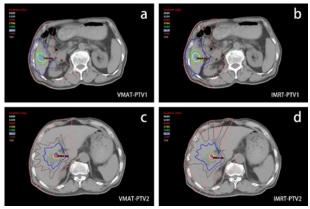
Dose distributions of axial computed tomography scans for VMAT and IMRT plans for one case. (a) Isodose lines of the VMAT plan for PTV1, (b) isodose lines of the IMRT plan for PTV1, (c) isodose lines of the VMAT plan for PTV2, (d) isodose lines of the IMRT plan for PTV2. Isodose lines show 110% (66 Gy, white), 105% (63 Gy, cyan), 100% (60 Gy, red), 95% (57 Gy, yellow) and 90% (54 Gy, green) of the prescription dose and 21 Gy (blue), 15 Gy (brown) and 7 Gy (pink) isodose lines.
